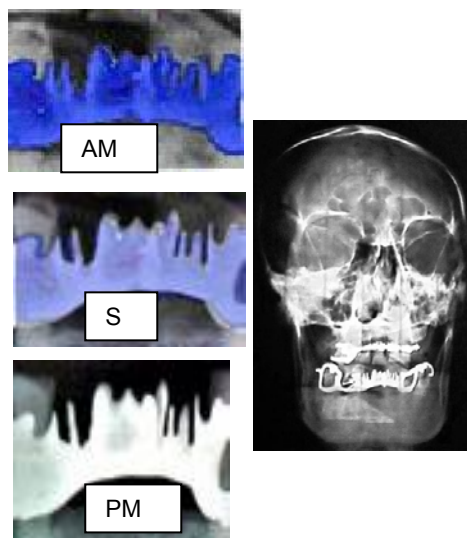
On the right the AM x-rays of the skull that shows both prostheses in the mouth. On the left the AM and PM radiographs of the anterior part of the mandible. The AM image is a detail of the x-rays of the skull. In the middle the superimposition (S) show (50% of translucency) of the AM and PM images alternatively coloured for simplifying the visualization.
